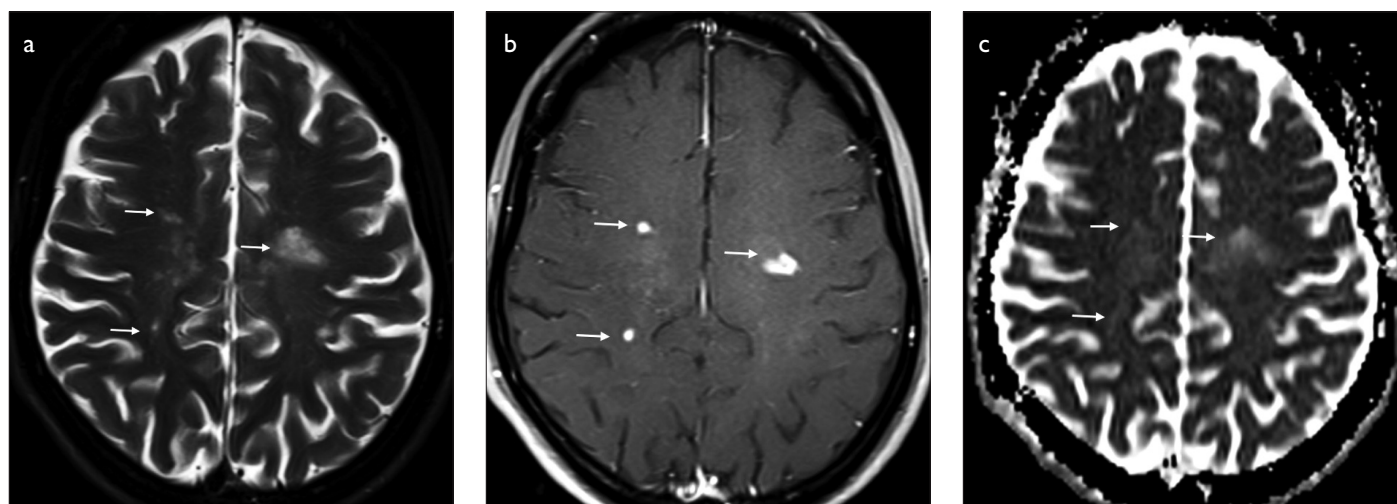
a-c. a) Axial plane T2-weighted image of a patient with active MS lesions at both centrum semiovale (arrows). b) Axial plane contrast enhanced image of a patient with active, enhancing MS lesions at both centrum semiovale (arrows). c) Axial plane ADC map of a patient with active MS lesions at both centrum semiovale. Lesions show no diffusion restriction (arrows).
